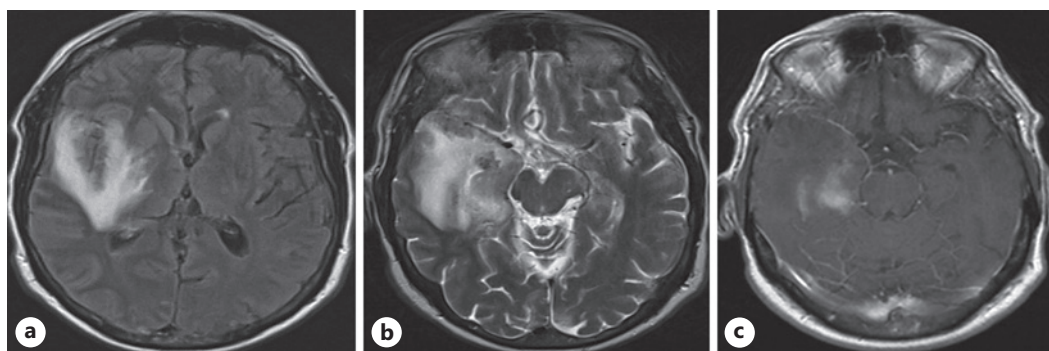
a, b Axial T2WI demonstrates gyral swelling and hyperintensities in the right mesial temporal lobe, in particular the uncus and part of the hippocampus consistent with encephalitis. c Axial FLAIR demonstrates hyperintensities in the same areas. d Axial ADC map shows facilitated diffusion in the right mesial temporal lobe.
